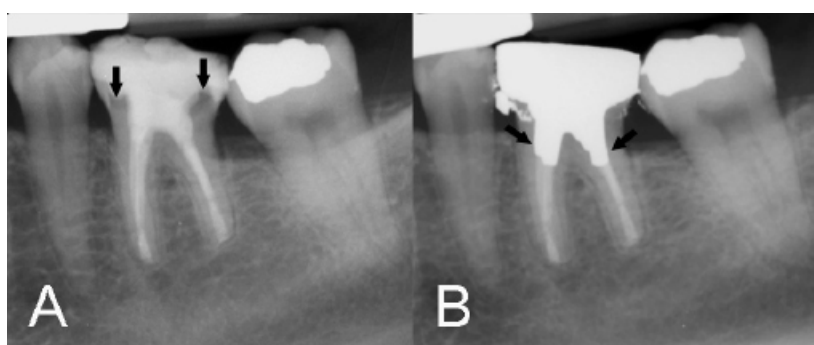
Long-term follow-up and management of recurrent caries. A) Periapical radiograph at 12-year follow-up (2025) showing recurrent coronal caries (black arrows) but otherwise excellent periapical health, intact periodontal ligament space, and no evidence of pathology. B) Immediate postoperative periapical radiograph after placement of an amalgam crown, showing tight intraorifice barriers (black arrows) and excellent marginal adaptation/restoration.
